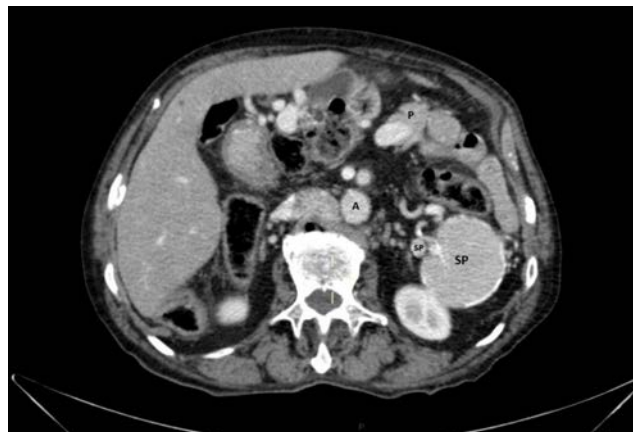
The abdominal computed tomography (CT) scan showing the aorta (A), the head of the pancreas (P) and spleens (SP).
